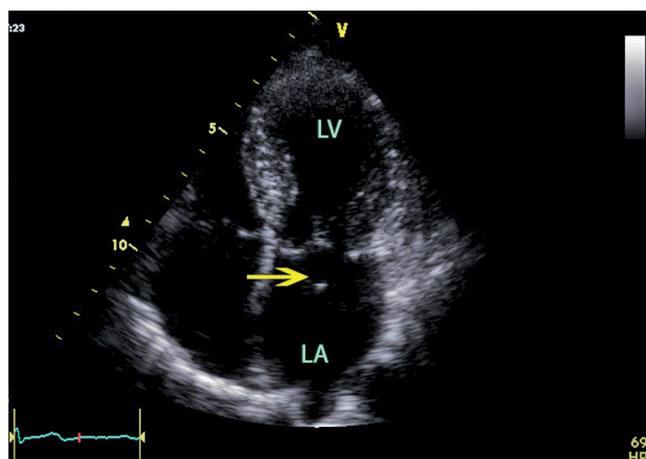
Transesophageal echocardiography in the apical 4-chamber view shows the site of the avulsion (arrow).
